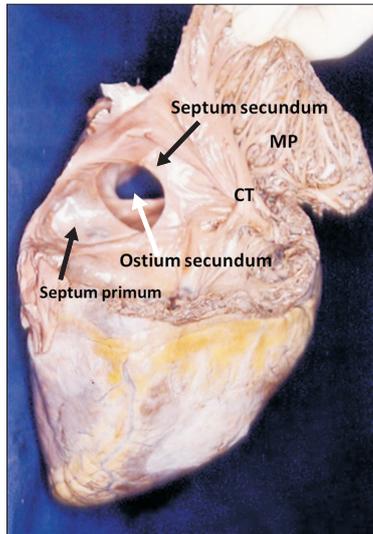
Interior of the right atrium showing the large ostium secundum defect. Crista terminalis (CT) and musculi pectinati (MP) can also be seen.
